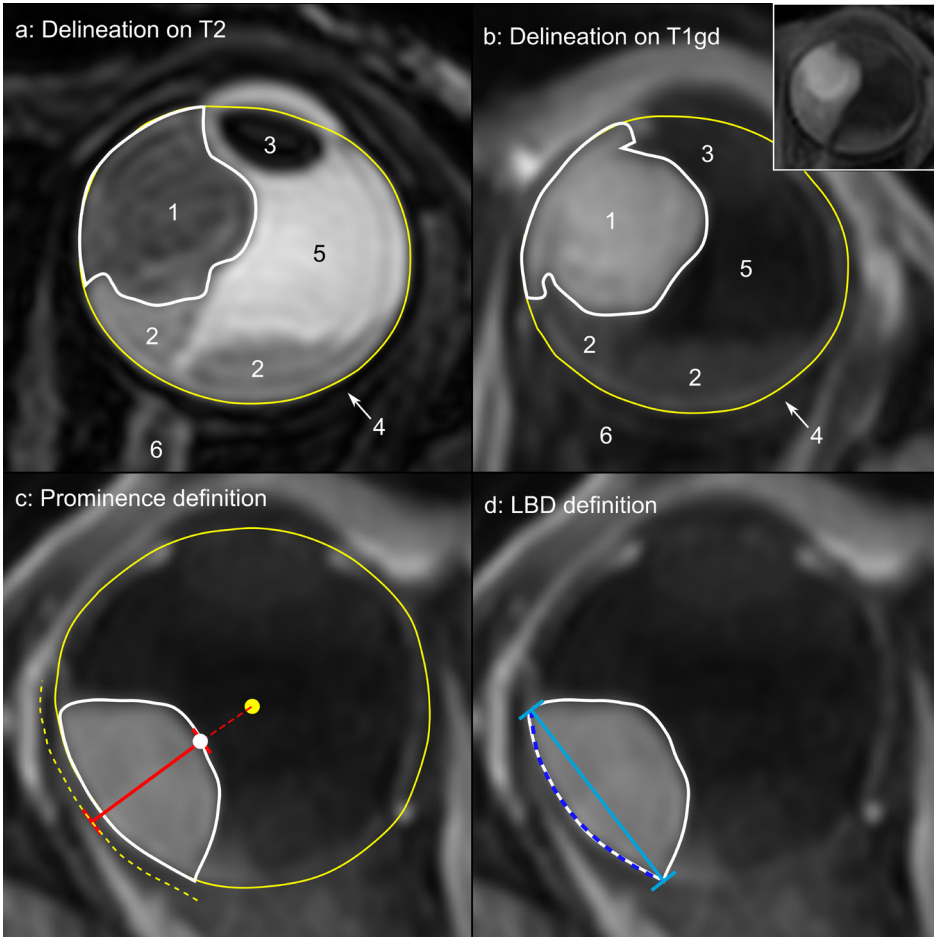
Tumour (white contour) and globe (defined as combination of vitreous, lens and tumour, yellow contour) were delineated on T2-weighted (a) and contrast-enhanced T1-weighted (T1gd) (b) images, with the native T1-weighted image used as a reference (inset). Anatomical structures are marked as follows: (1) tumour, (2) retinal detachment, (3) lens, (4) sclera (hypointense layer), (5) vitreous, (6) optic nerve. Tumour prominence (c, red line) and largest basal diameter (d, blue line) were automatically determined. (c) Tumour prominence was measured from the tumour apex (white dot) to the sclera (dashed yellow line) (centre-based definition, Appendix A). (d) LBD was the largest Euclidean distance between two points in the tumour base (base: dashed line, measurement: solid line). In this image, the axial plane was shown as an example, whereas the tumour delineation was evaluated in the axial, sagittal and coronal plane.
